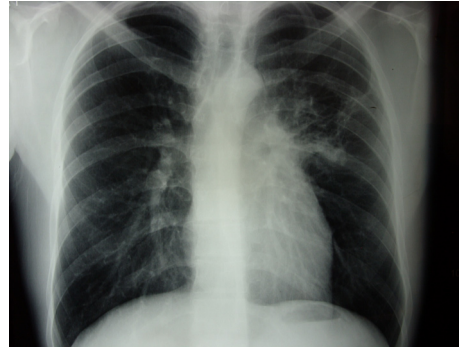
The P/A chest x-ray taken after therapy.
